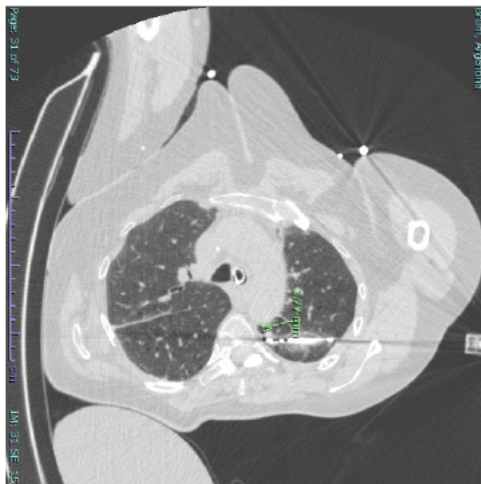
CT scan image after applying positive pressure to the non-ventilated left lung.
